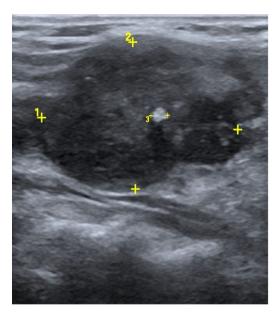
Cervical Ultrasonography: a heterogeneous hypoechoic nodule with calcifications measuring $33 \times 27 \times 25$ mm in the right thyroid lobe.
